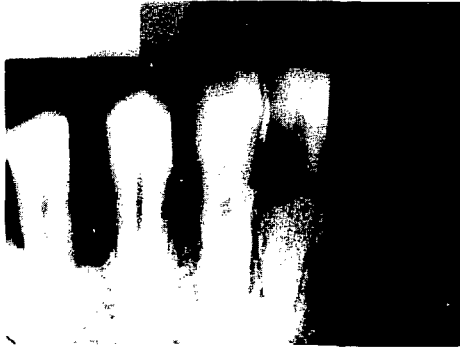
Radiograph of the lesion between cuspid and premolar with the buccal and the lingual wall still intact.
